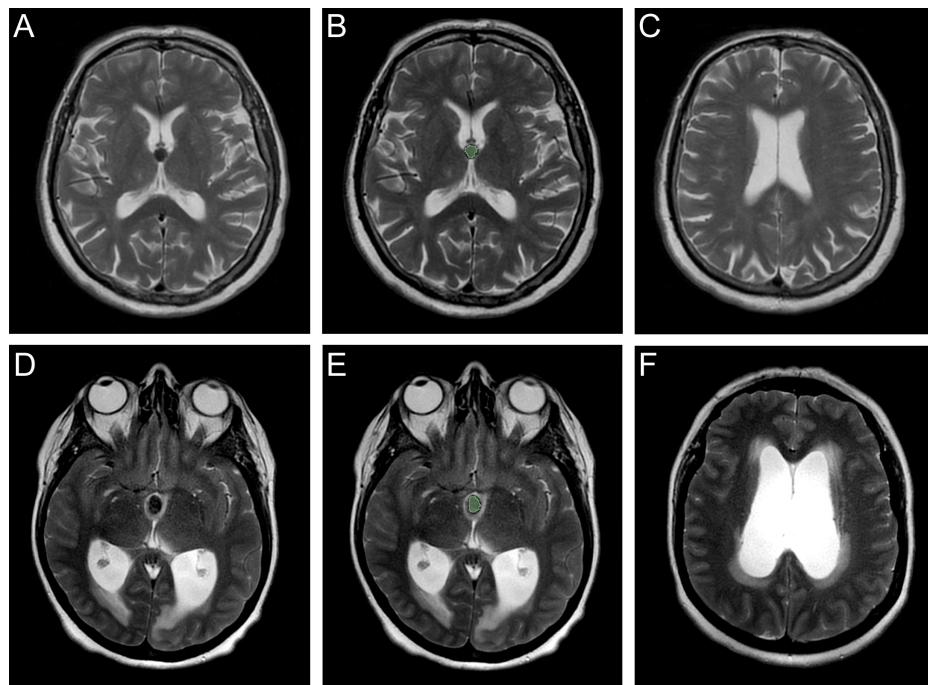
(A and B) Colloid cyst and segmentation are seen on T2-weighted magnetic resonance images in a 49-year-old female patient. C It is observed that ventricle dimensions are normal in the same patient. (B and E) A 71-year-old female patient has a colloid cyst and its segmentation on T2-weighted magnetic resonance images. (F) Hydrocephalus is seen in the same patient.
